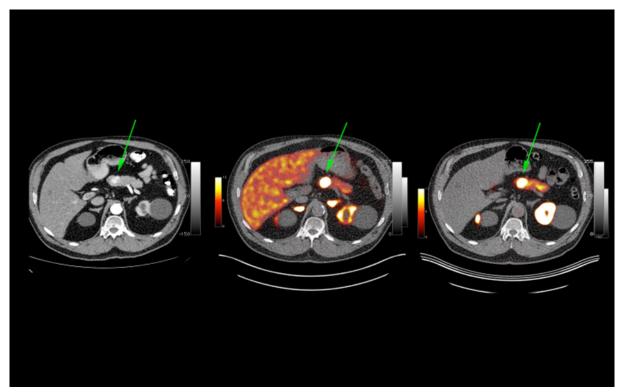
Localization studies demonstrating a localized insulinoma. From left to right: arterial-phase contrast-enhanced CT, ⁶⁸Ga-DOTATATE PET-CT, ⁶⁸Ga-NODAGA-exendin PET-CT (Courtesy: Drs. Marti Boss and Martin Gotthardt, Radboud University Medical Centre, Nijmegen, the Netherlands).
